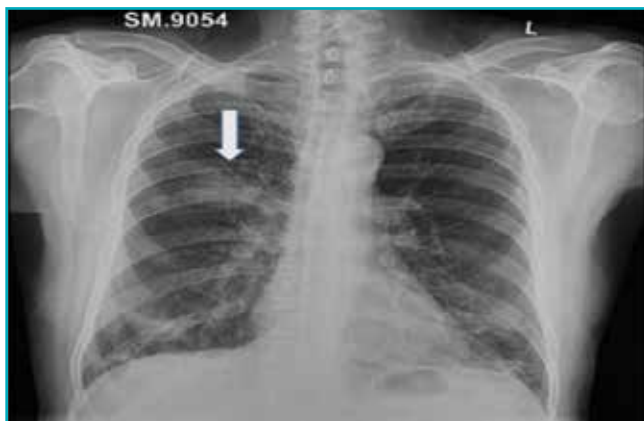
Chest X-ray (anteroposterior view) showing an ill-defined opacity in the right perihilar region, with thin atelectatic linear bands in the lower zones of the right lung (white arrow).
